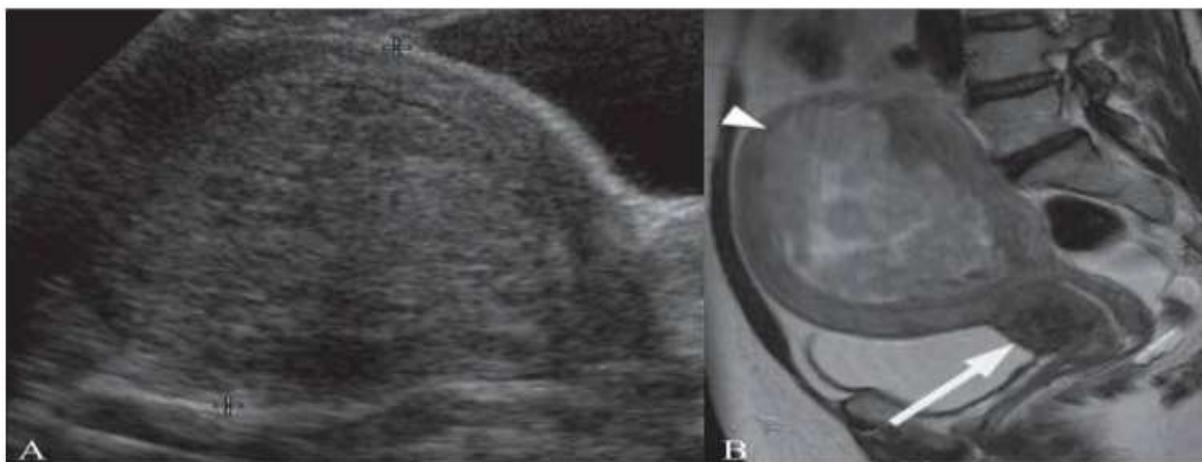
Image no: 1 Transabdominal (TA) USG image (A) shows a submucosal fibroid Sagittal T2W MRI image (B) in the same patient shows that the submucosal fibroid
